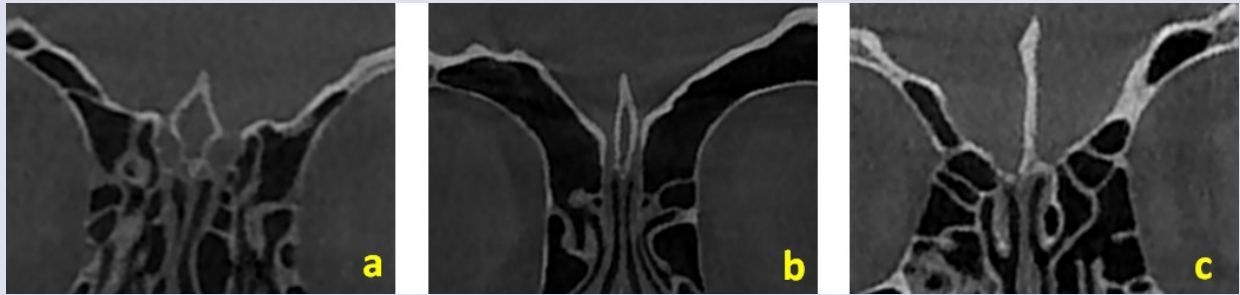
Morphological classification of CG on coronal CBCT slices. a) Teardrop type. b) Tubular type. c) Ossified type.
